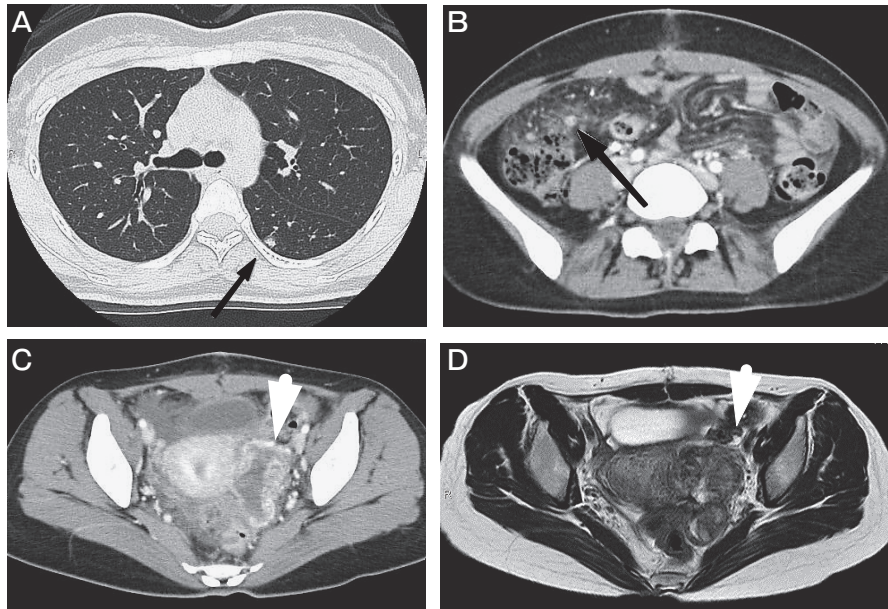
Computed tomography (CT) showed lung metastasis of 5 mm (A) and peritoneal dissemination (B). CT and magnetic resonance imaging (MRI) showed a mass of 58 mm in her left pelvis (C and D).
